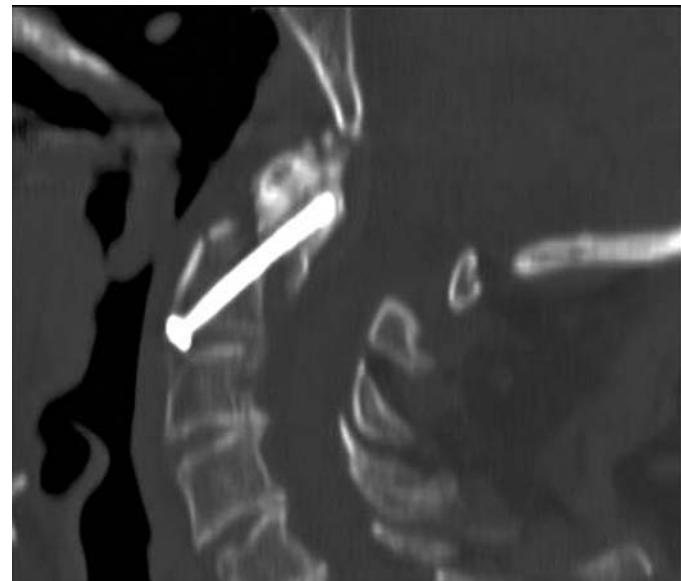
Sagittal CT scan showing loss of position on postoperative day 4.
